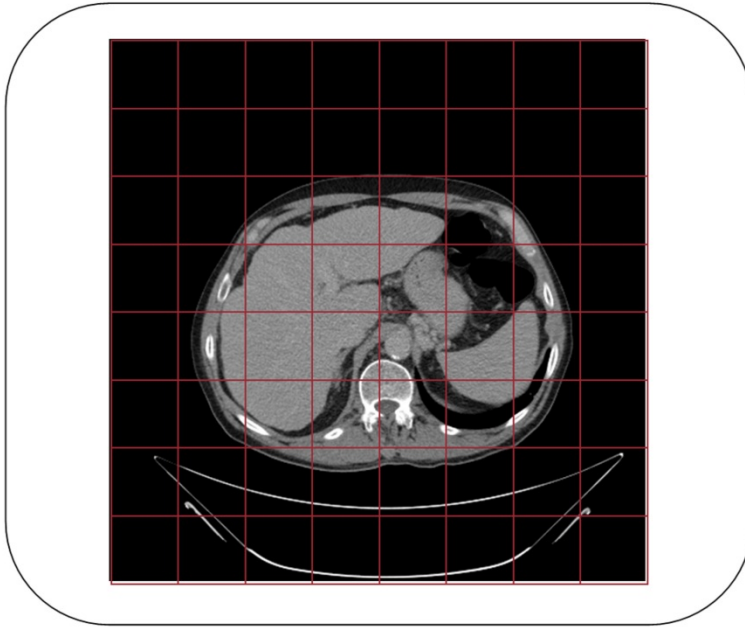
CT slice is divided into 64 squared regions
